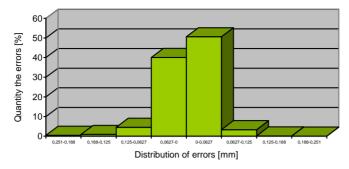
Histogram of the distribution of errors of the radius measurements of ceramic reference balls resulting from measurement on CT.
